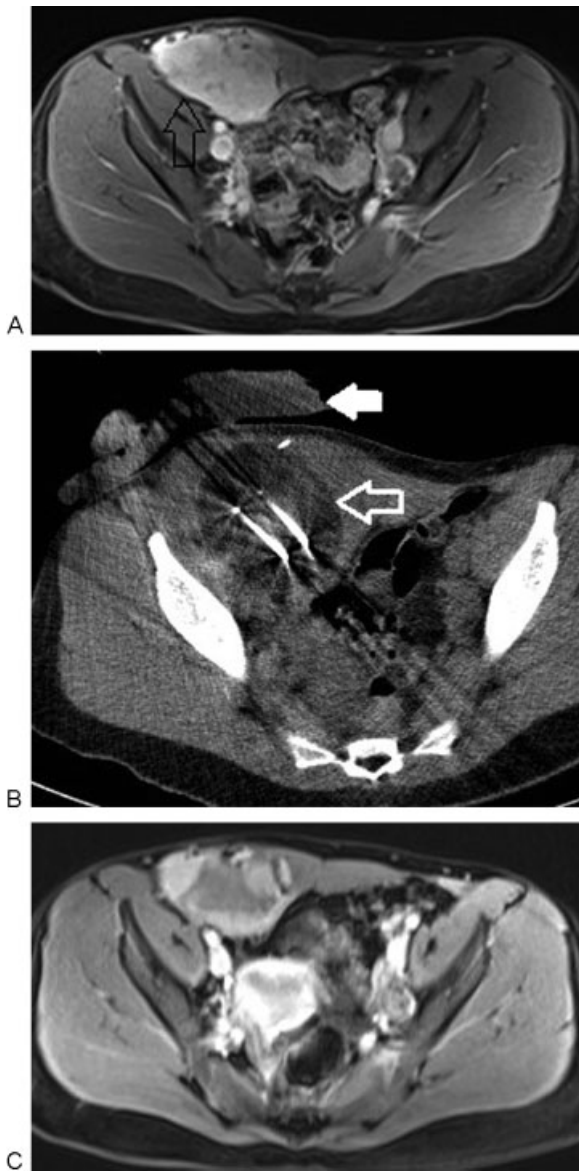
A 24-year-old woman professional dancer with recurring abdominal wall desmoid since the age of 12, now causing pain and inability to perform. She underwent multiple surgeries and chemotherapy. (A) Pretreatment MRI with large right rectus desmoid (arrow) with adjacent small bowel. (B) Cryoablation probes and ice ball formation (open arrow) with hydrodissection interface medially to protect bladder and bowel. Overlying gloves with warmed saline were placed for thermal skin insulation (solid arrow). (C) Six-month post-treatment scan demonstrating decreased tumor size and firmness, which allowed the patient to resume her dancing career. MRI, magnetic resonance imaging.
